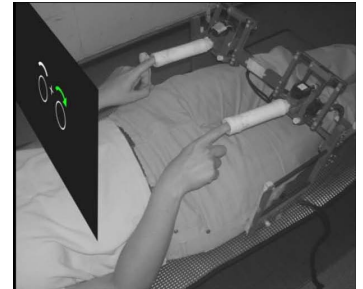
Task performed in the MRI scanner. Subject position and custom MRI compatible joysticks are shown.
